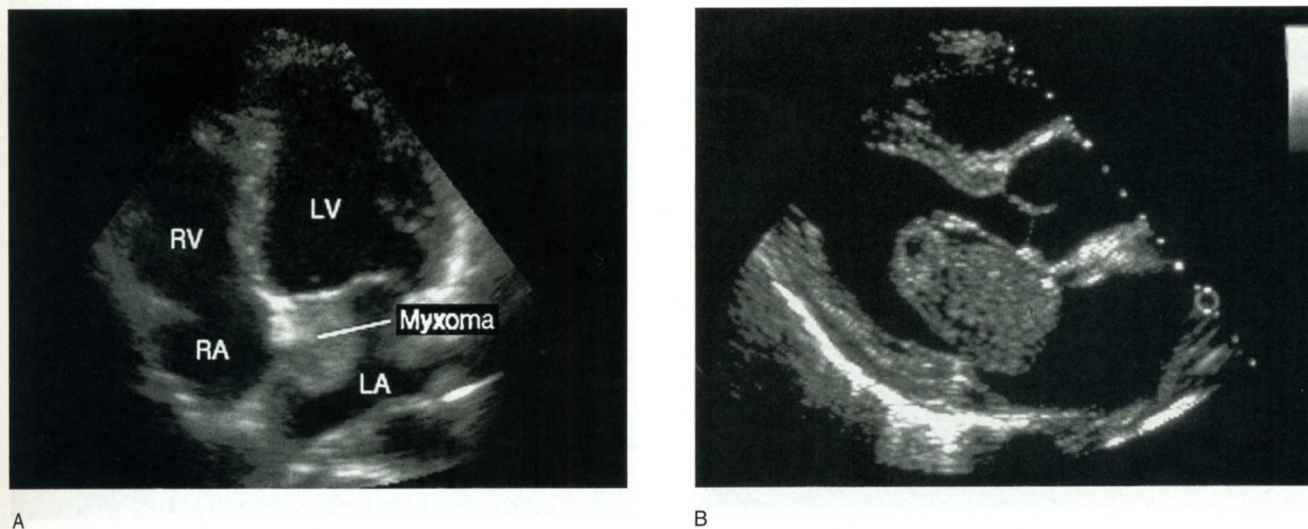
Left atrial myxoma shown on apical four-chamber view (A). Left atrial myxoma shown on a parasternal long-axis view (B). The mass was mobile and prolapsing into the LV on the real-time exam. (Courtesy of Lori Sens and Lori Green, Gulfcoast Ultrasound)
